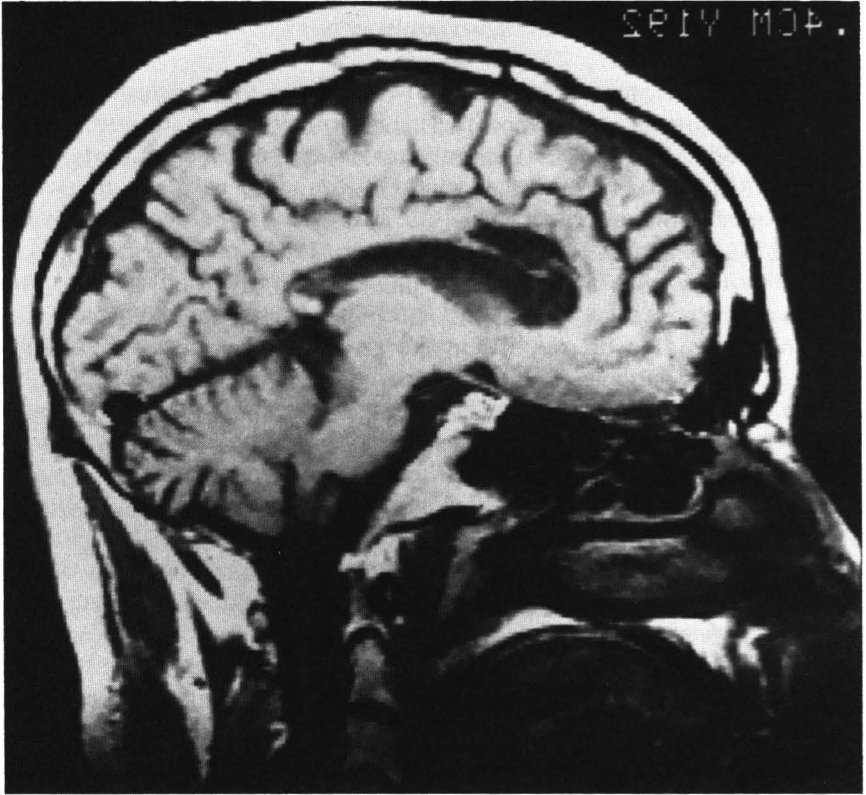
MRI of case J. Kn. This patient was presumed split until MR imaging revealed a clearly intact splenium. The patient transfers visual but not tactile information between the two hemispheres. (Special thanks to William Abend, M.D. of Harvard Medical School for arranging this scan.)
